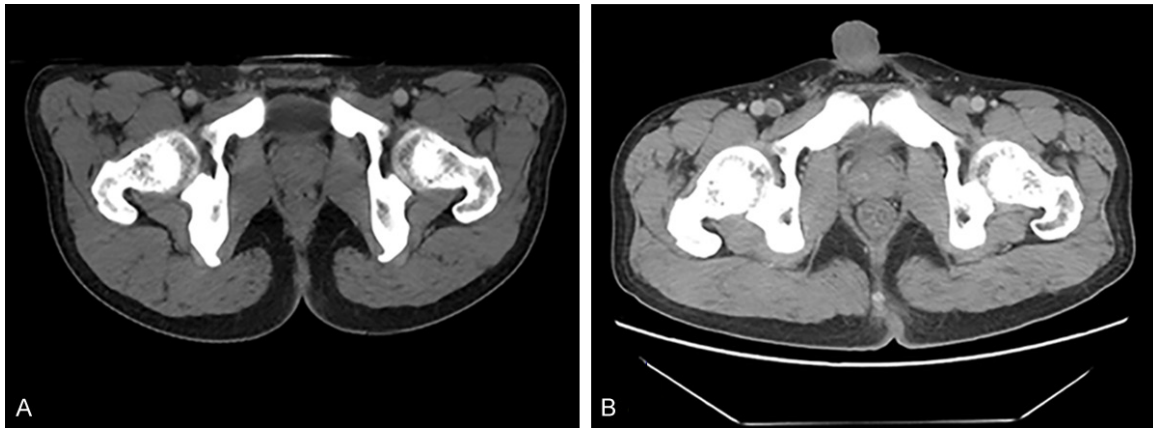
(A) CT before chemo-radiotherapy and (B) CT of 6 months after sphincter-sparing lower anterior resection.
